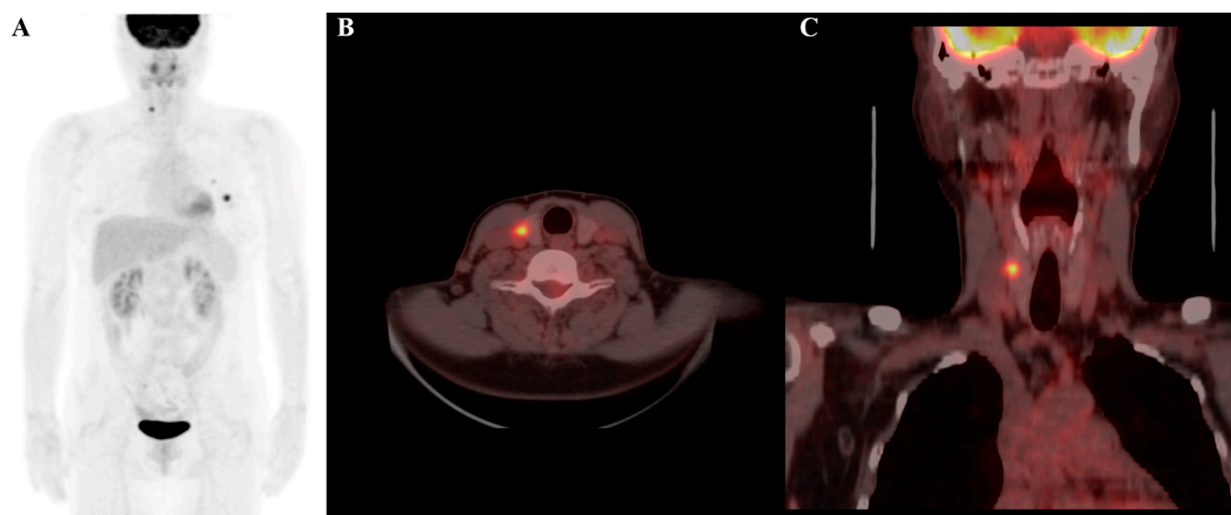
F-18 FDG PET/CT image of a 56-year-old female patient, showing a thyroid incidentaloma located in the right lobe of the thyroid gland: (A) maximum intensity projection (MIP); (B) axial PET/CT image; and (C) coronal PET/CT image. The lesion exhibits elevated FDG uptake, with a maximum standardized uptake value (SUVmax) of 7.3. Radiomic analysis reveals a log-sigma-2-0-mm-3D_glszm_SmallAreaEmphasis value of 0.734 (relatively high) and a wavelet-HLH_gldm_LargeDependenceLowGrayLevelEmphasis value of 4.440 (relatively low). The final diagnosis confirmed that the nodule was malignant.
